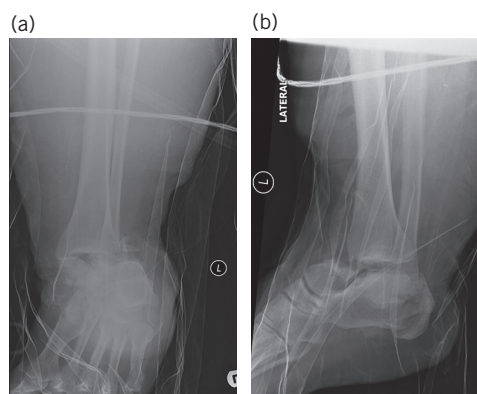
Plain radiographs showing talus fracture dislocation sustained from initial road traffic accident injury: a) anteroposterior view; b) lateral view.
